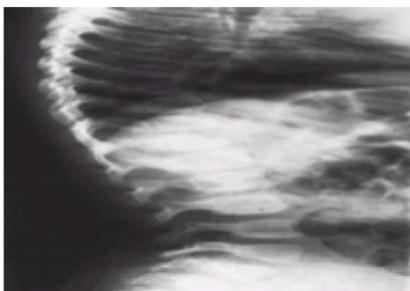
The lateral radiograph of a girl 2 years and 1 month of age with eosinophilic granuloma of T12. Note the vertebra plana with maintenance of the disk space height.
